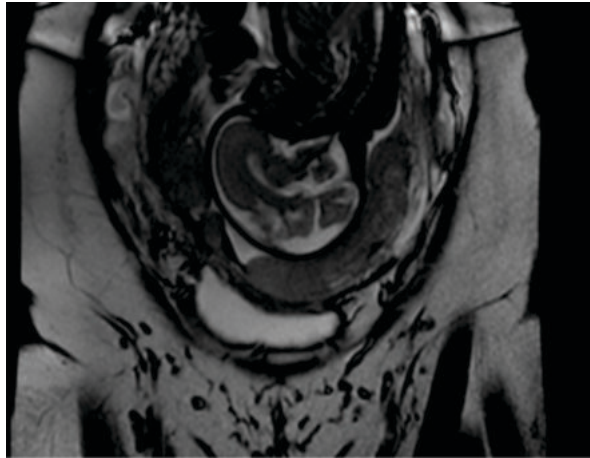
MRI Image Showing An Exophytic Nodule Superior To The Urinary Bladder, Extending Up To The Serosal Surface-placenta Percreta
